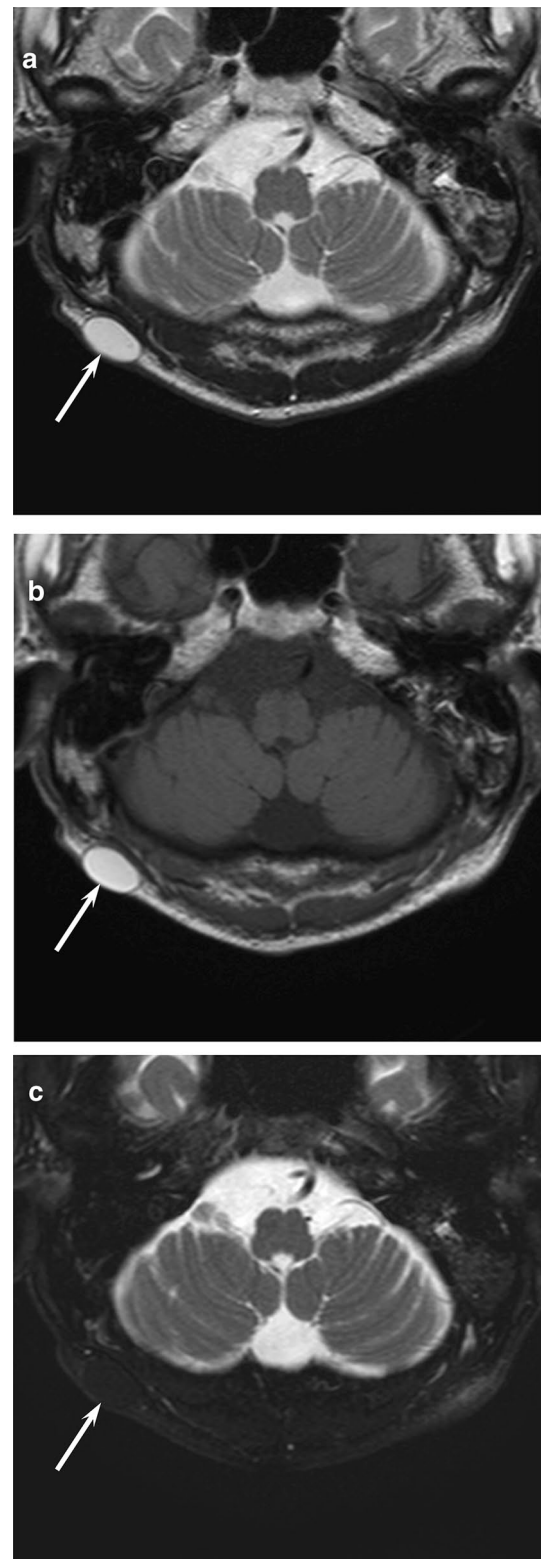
A 66-year-old man with sebaceoma. a T2-weighted image shows a well-demarcated, homogeneously hyperintense, subcutaneous lesion (arrow). b T1-weighted image shows homogeneous hyperintensity (arrow). c Fat-suppressed T2-weighted image shows decreased signal intensity (arrow)
